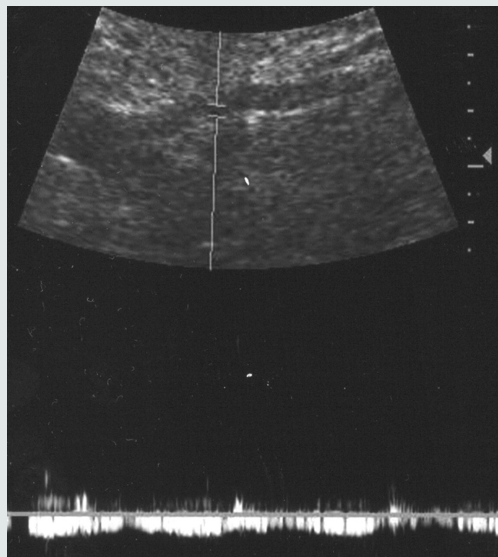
Spectral Doppler waveform of the ovarian vein in a non-gravid female.<sup>9</sup>
